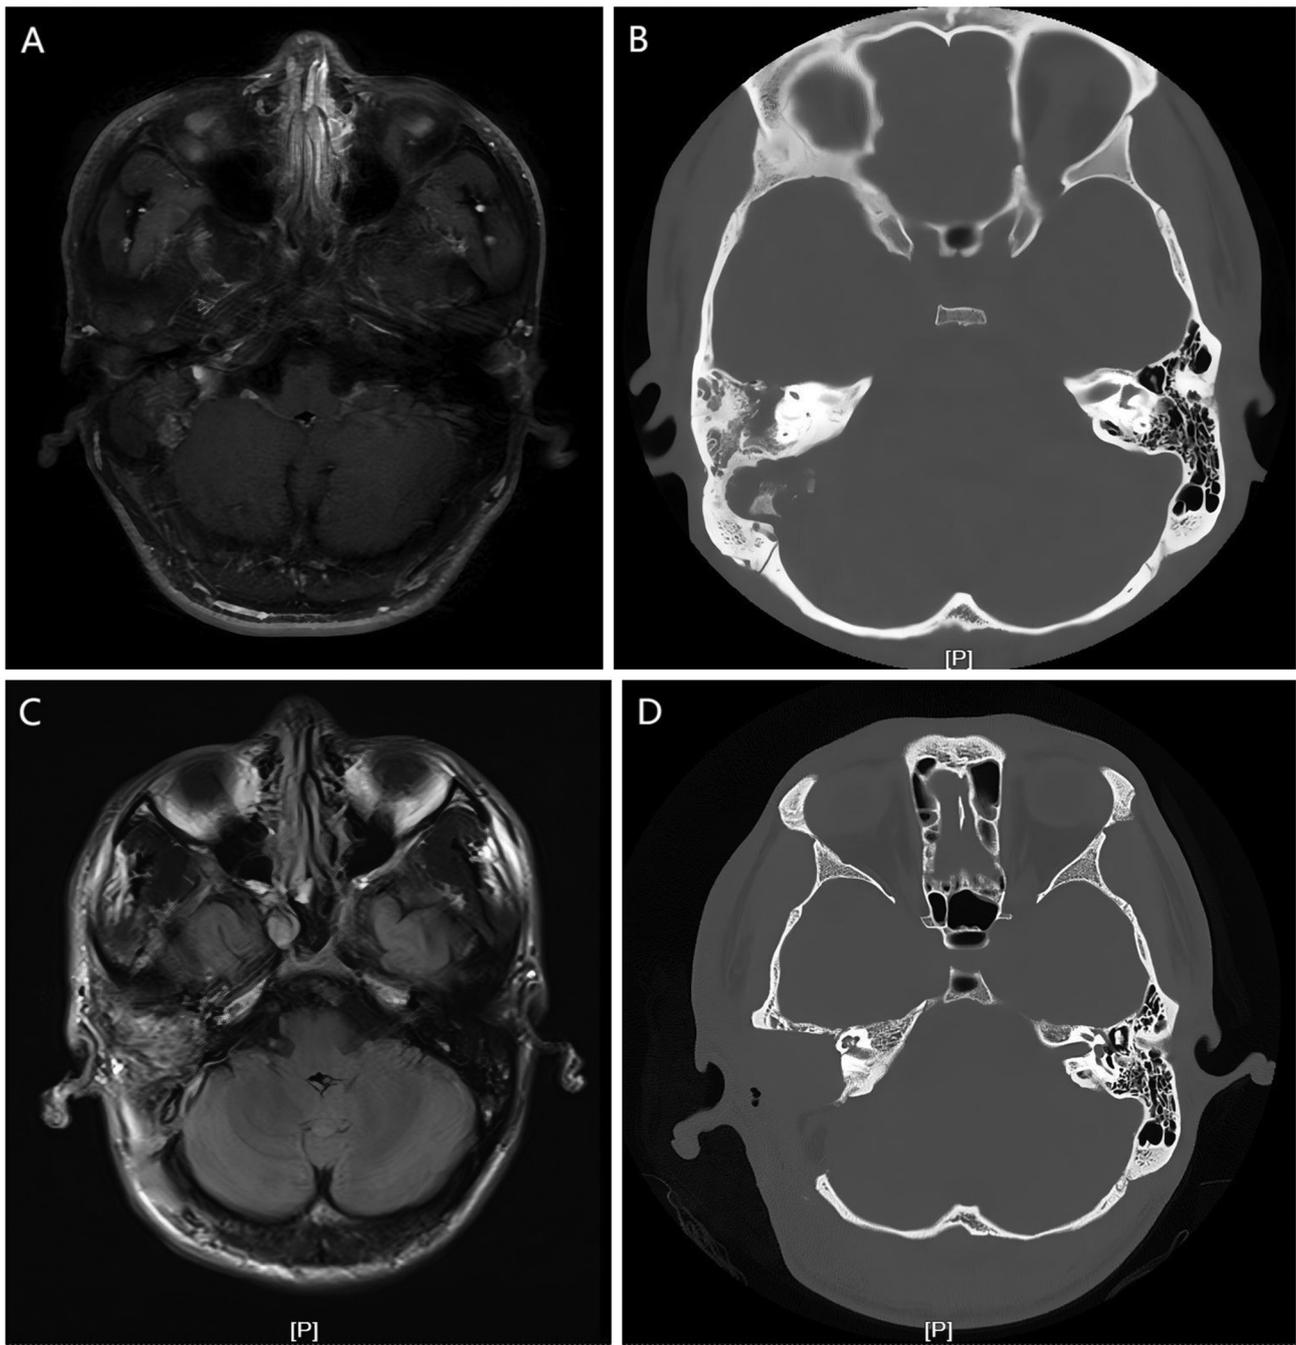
Imaging studies of a patient with chondrosarcoma diagnosed at 28 years old. (A and B) Preoperative contrast-enhanced MRI and CT images showing the invasion of the tumor to the middle ear and sigmoid sinus. (C and D) Post-operative contrast-enhanced MRI and CT images. MRI, magnetic resonance imaging; CT, computed tomography.
